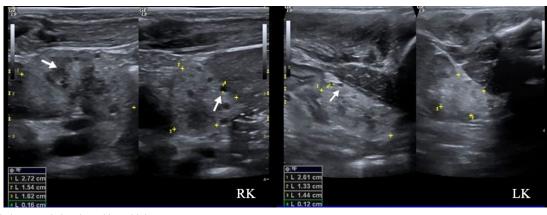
Renal ultrasound showing with multiple cysts. Abbreviations: RK: Right kidney; LK: Left kidney.
